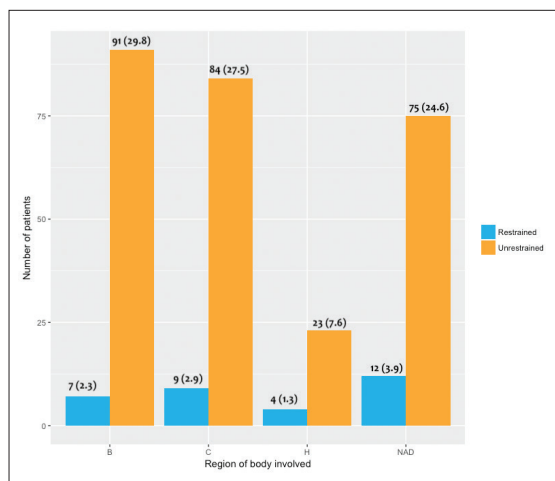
Pattern of injuries on pan-CT scans in road traffic accident patients (NAD: no abnormality detected, H: isolated or combined head, face and neck, C: isolated or combined chest, abdomen and pelvis, and B: both regions. Number and percentage at top of bar) ($P=.43$).
